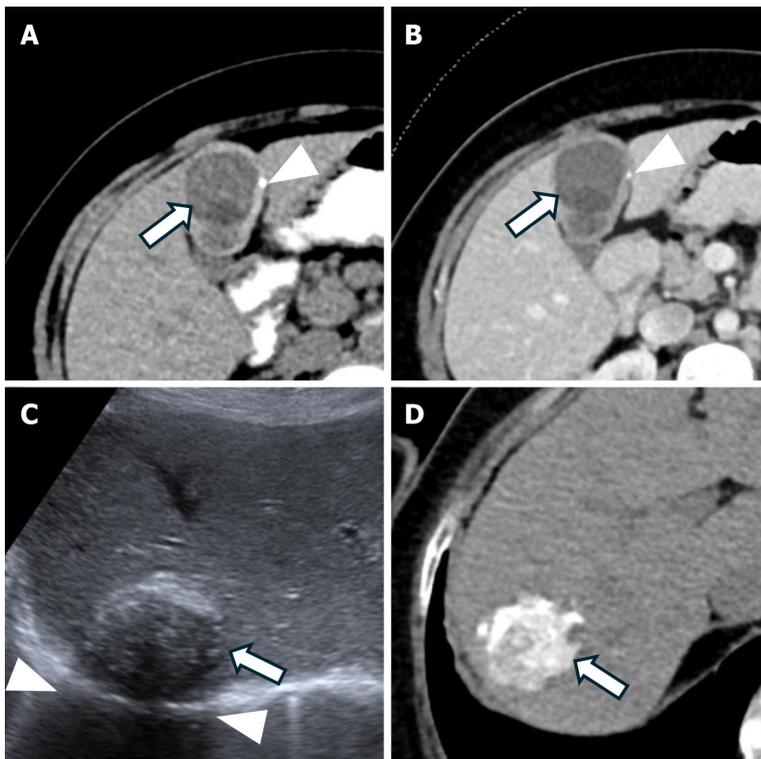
Inactive hydatid cysts. A: Axial non-contrast computed tomography (CT) image shows a heterogeneous hypodense hydatid cyst (arrow) with a partially calcified wall (arrowhead); B: Axial contrast-enhanced CT image shows a heterogeneous hypodense hydatid cyst (arrow) with a partially calcified wall (arrowhead); C: Ultrasound image of another patient demonstrates a heterogeneous calcified hydatid cyst (World Health Organization type CE5, arrow) with acoustic shadowing (arrowheads); D: Axial non-contrast CT image shows a calcified hydatid cyst (arrow).
